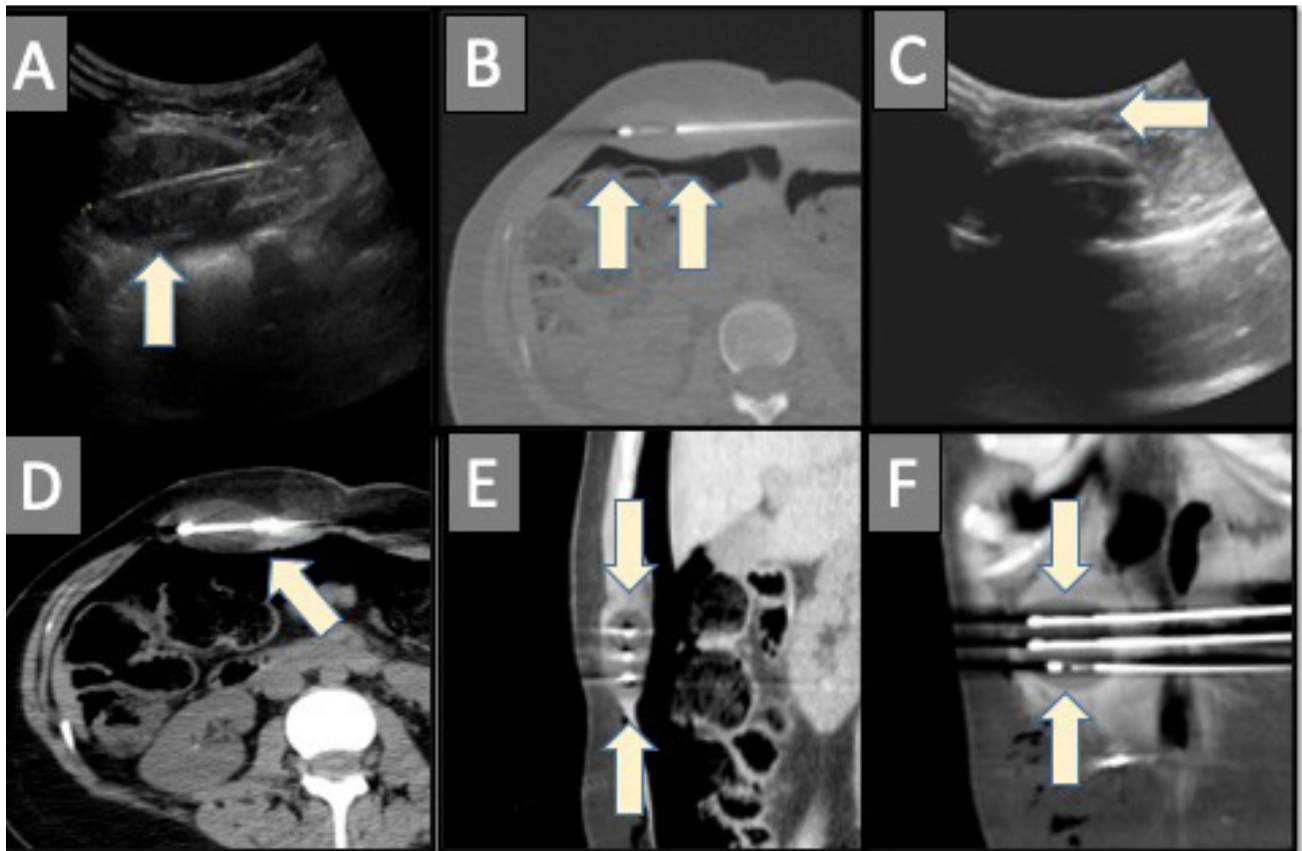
(A) First cryoablation of the inferior half of the desmoid with cryoablation probe placement under ultrasound guidance into the lesion (arrow). (B) Injection of carbon dioxide into the peritoneum displaced the underlying bowel (arrows). (C) Cryoablation was performed under frequent ultrasound monitoring to ensure coverage of the inferior portion of the tumor while maintaining adequate separation between the dermis and the most superficial portion of the therapeutic ice ball (arrow). (D, E, F) Computed tomography monitoring was done to confirm coverage of the tumor and persistent separation of underlying bowel by intermittent reinjection of carbon dioxide (arrows).
